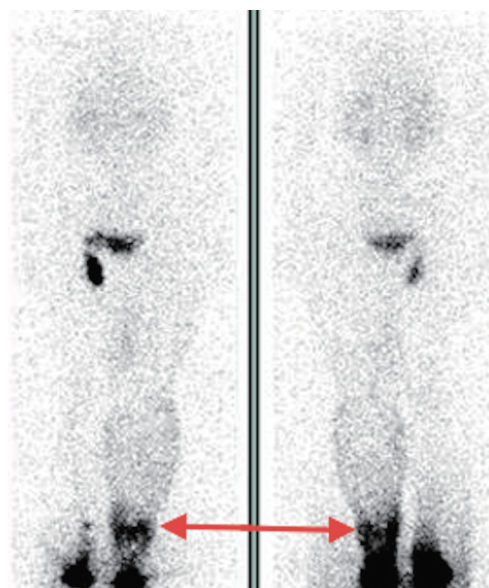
Lymphatic obstructions near the transferred flap. Lymphoscintigraphy revealed lymphatic obstructions at the level of the transferred flap (red arrow).
